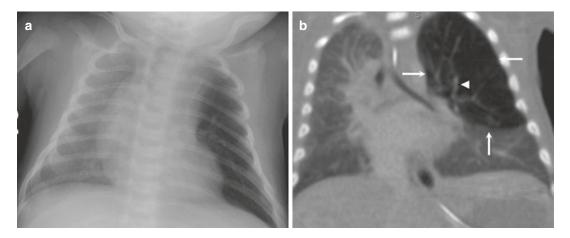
Congenital lobar overinflation: (a) Chest radiograph shows left upper lobe lucency with mediastinal shift to the contralateral side and compressive right lung atelectasis. (b) Coronal CT image in the same patient. Marked hyperinflation of the left upper lobe (arrows) with significant mediastinal shift and right lung atelectasis. Note that the vascularity (arrowhead) in the affected lobe is attenuated
